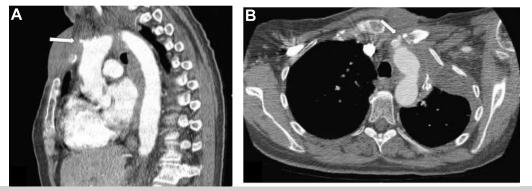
A, Computed tomography angiography (CTA) of the thorax (median sagittal view) demonstrating the mycotic pseudoaneurysm (MP). The *arrow* shows a small focus of contrast extravasation from the proximal innominate artery. B, The same CTA image (axial view) demonstrating contrast extravasation from the aortic arch consistent with an MP.
